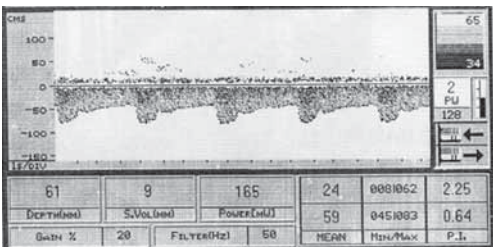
Transcranial continuous waveform Doppler of the left vertebral artery: there is a normal flow pattern, with normal peak systolic velocity (59 cm/s).
